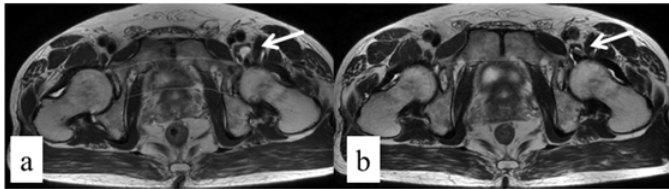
Post-operative magnetic resonance imaging.(a) A T2 weighted image (axial view) at 3 months after surgery, (b) A T2 weighted image (axial view) at 6 months after surgery.
